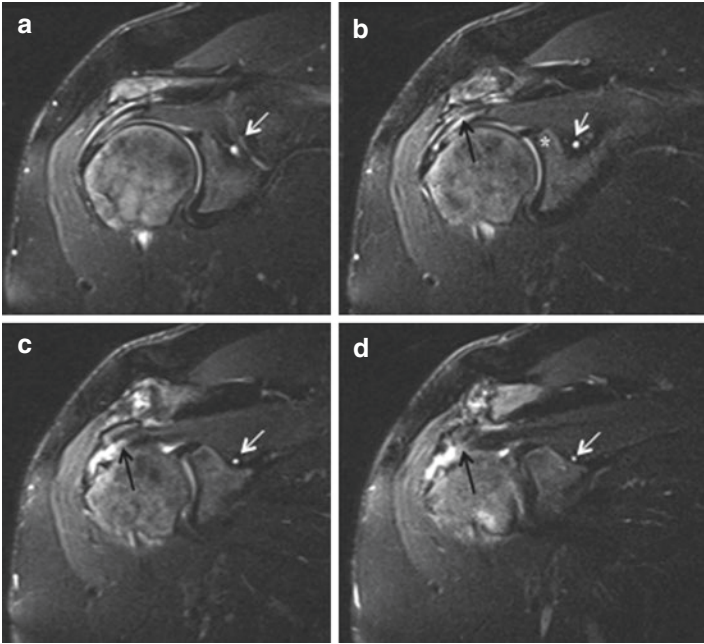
Sequential sagittal images of T2-weighted shoulder MRI demonstrating supraglenoid cyst (*white arrow*), superior labrum with linear signal intensity between labrum and glenoid rim (*asterisks*), and full-thickness tear of supraspinatus (*black arrow*)
